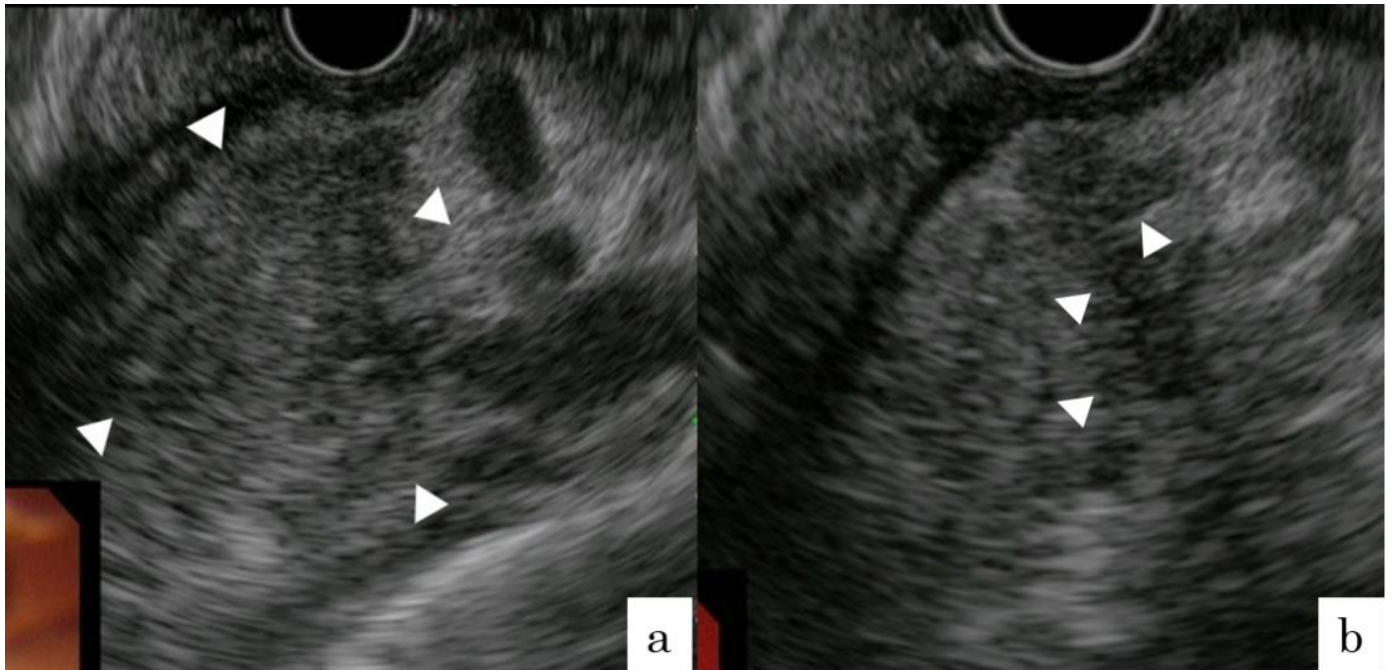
Endoscopic ultrasonographic findings in Case 1
